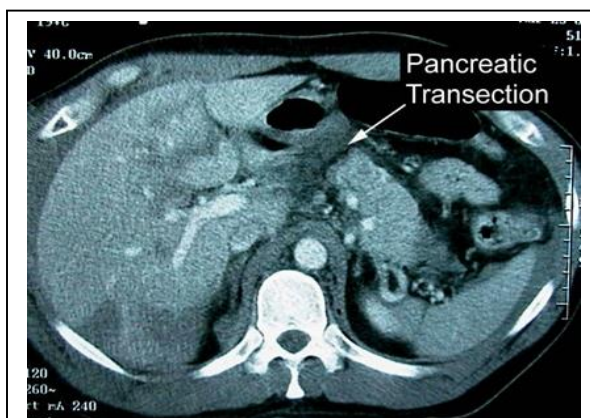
Axial contrast-enhanced computed tomography of patient's abdomen showing pancreatic transection with retroperitoneal hematoma
